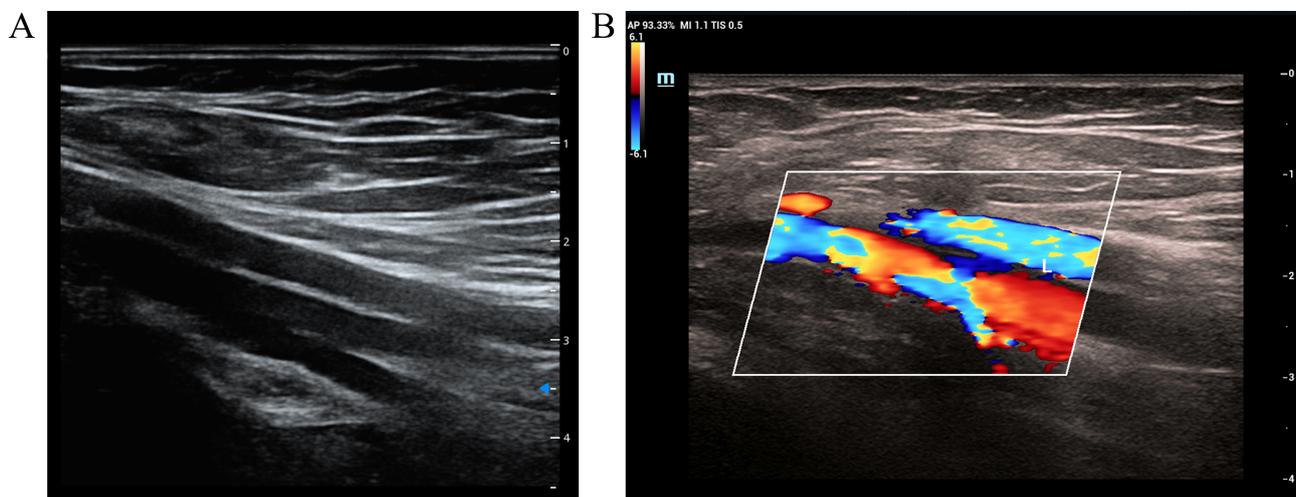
B-ultrasound of lower extremity veins before and after treatment in case 3. (A) Left common femoral vein thrombus before treatment. (B) Thrombus recanalization after thrombolytic therapy.
